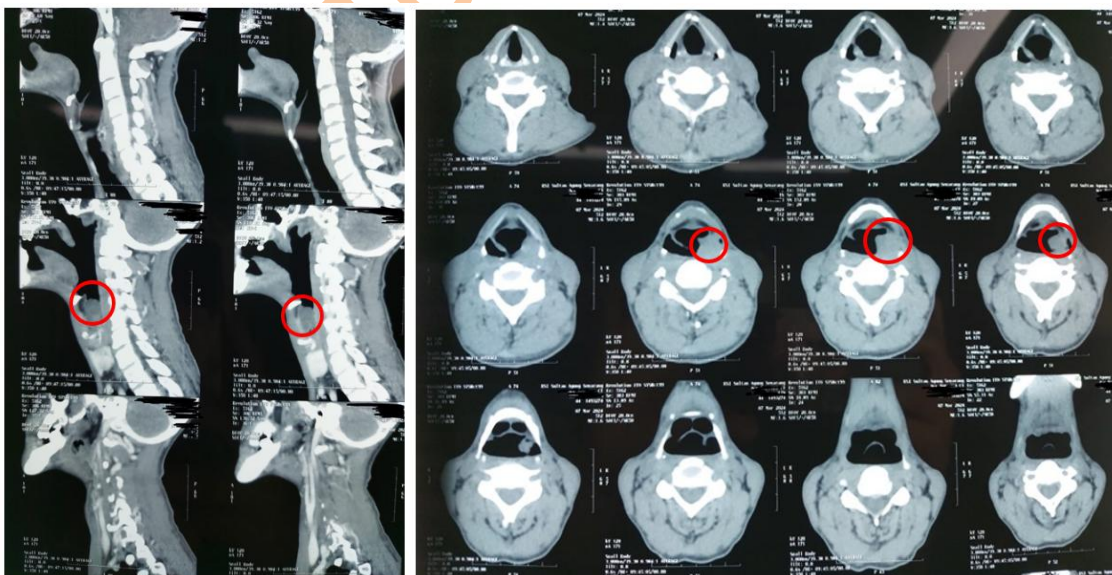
Sagittal and Axial Section CT Results for the Larynx. The CT results show a supraglottic tumor mass at the level of cervical vertebrae IV - VI, located on the left side of the epiglottis to the front of the left corniculate cartilage
